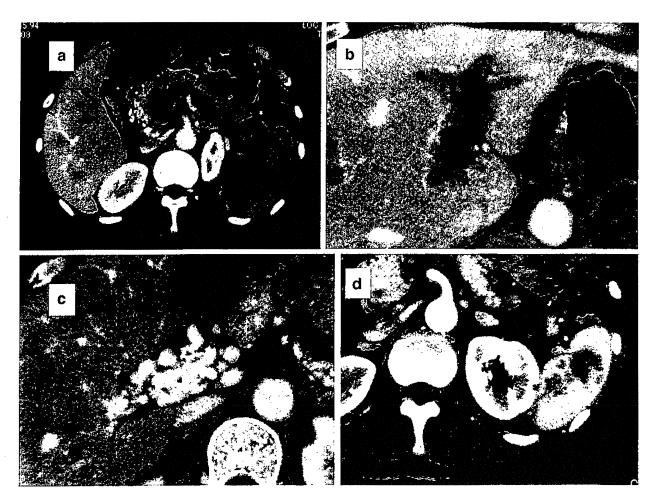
Abdominal CT findings before chemotherapy. a Huge tumor thrombosis was identified in the portal vein. b Tumor thrombosis extended
